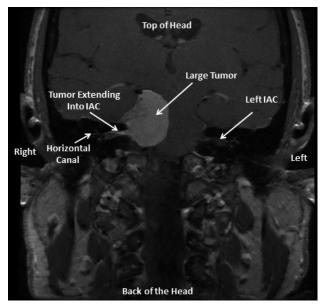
Coronal T1 post-gadolinium MRI image at the level of the internal auditory canal (IAC) showing extension of the mass into the IAC.
